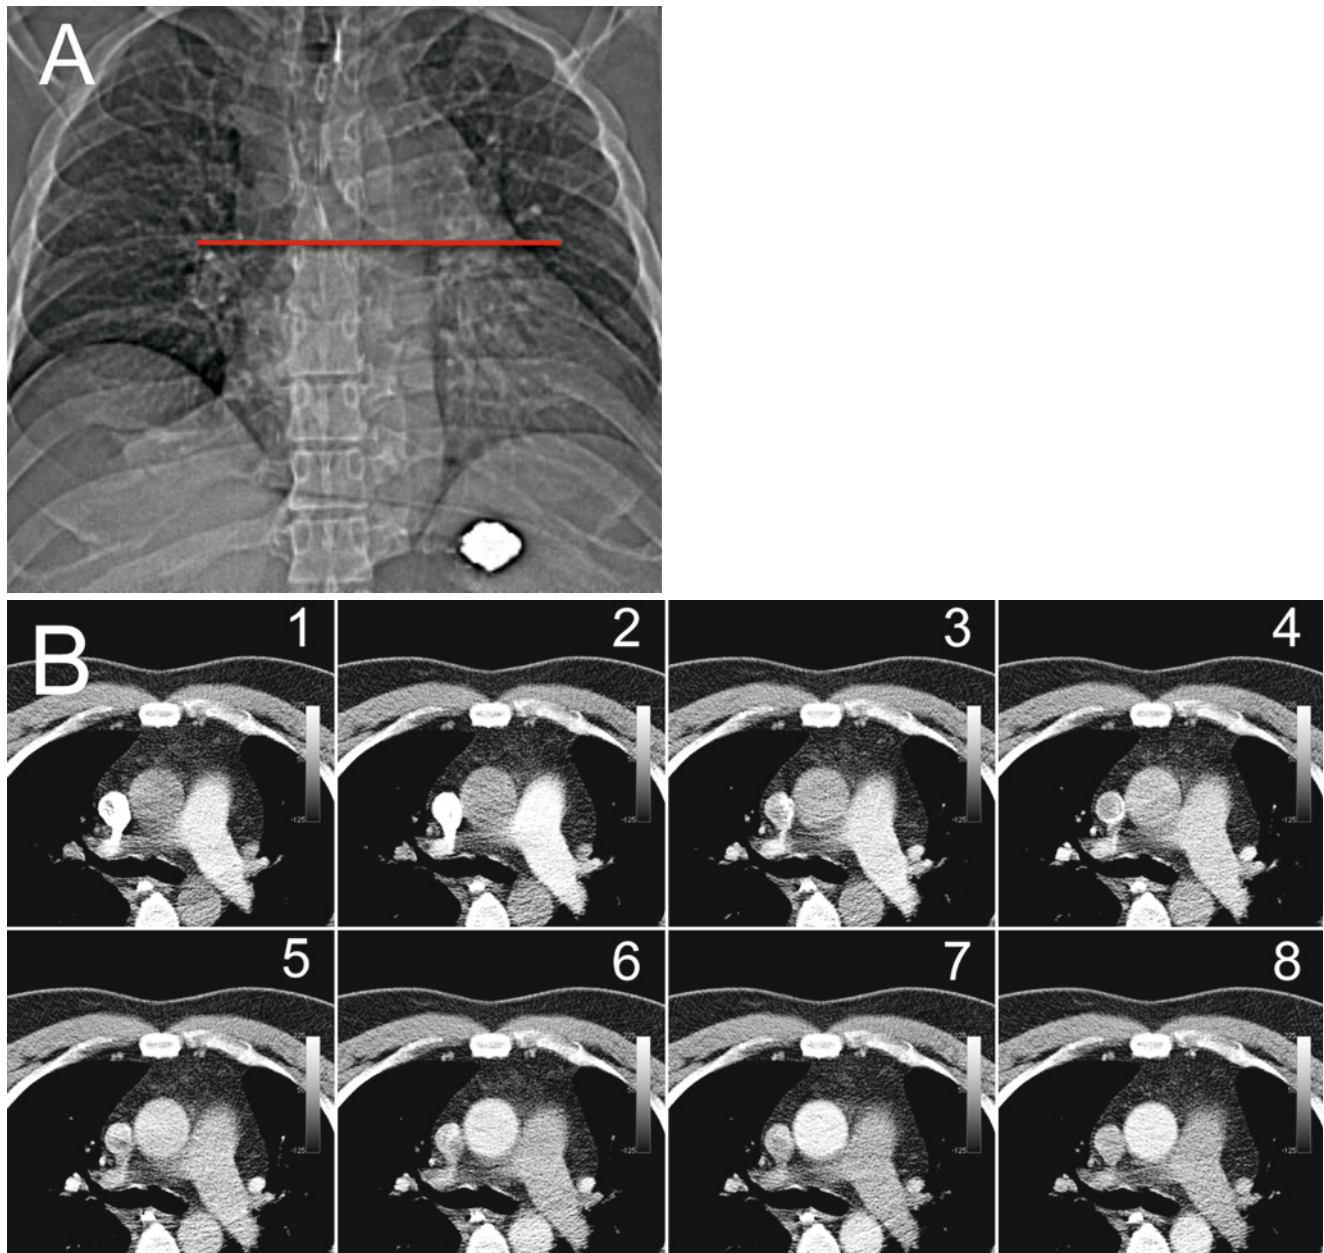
(a) Scout localization with a “topogram” is the first image acquisition of a CT scan. The red line is positioned at the image slice location for the test bolus or bolus tracking. At this slice level (approximately 1 cm below bifurcation of the carina), the ascending aorta and pulmonary artery should be in the field of view. Note the bright irregularly shaped circular density is the oral barium in the stomach.
